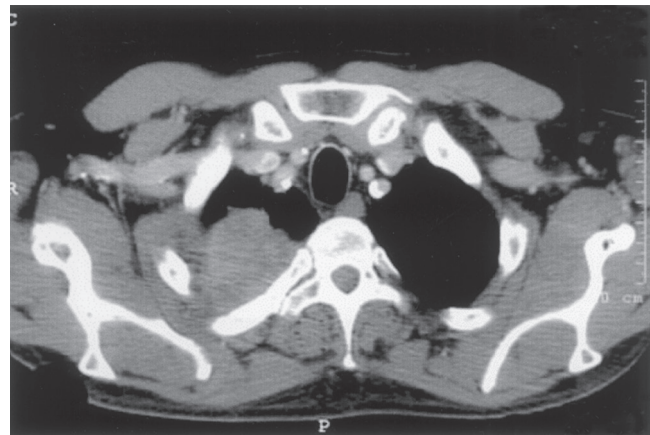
■ Computed tomographic scan showing a right superior sulcus bronchial carcinoma invading the posterior arch and the transverse process of the first rib and abutting the costovertebral angle.
